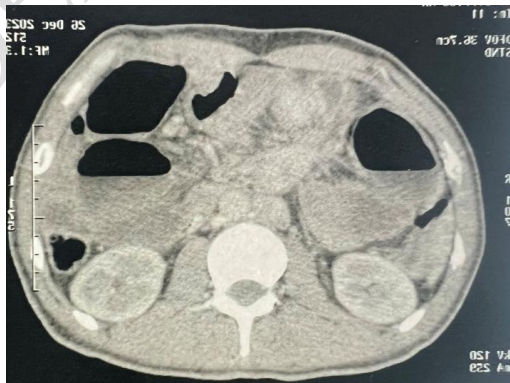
Emergency abdominal CT scan
